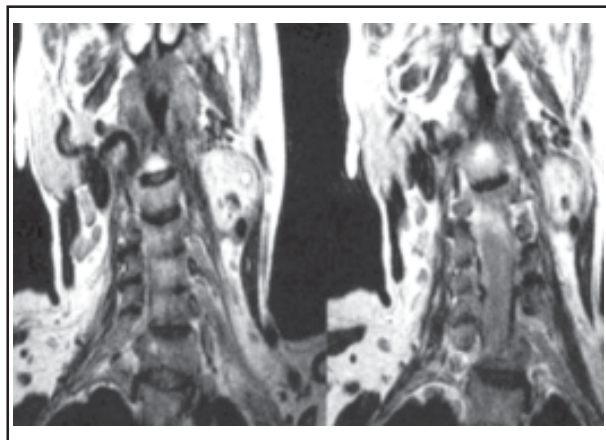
MR image of the neck of one of our patients.
